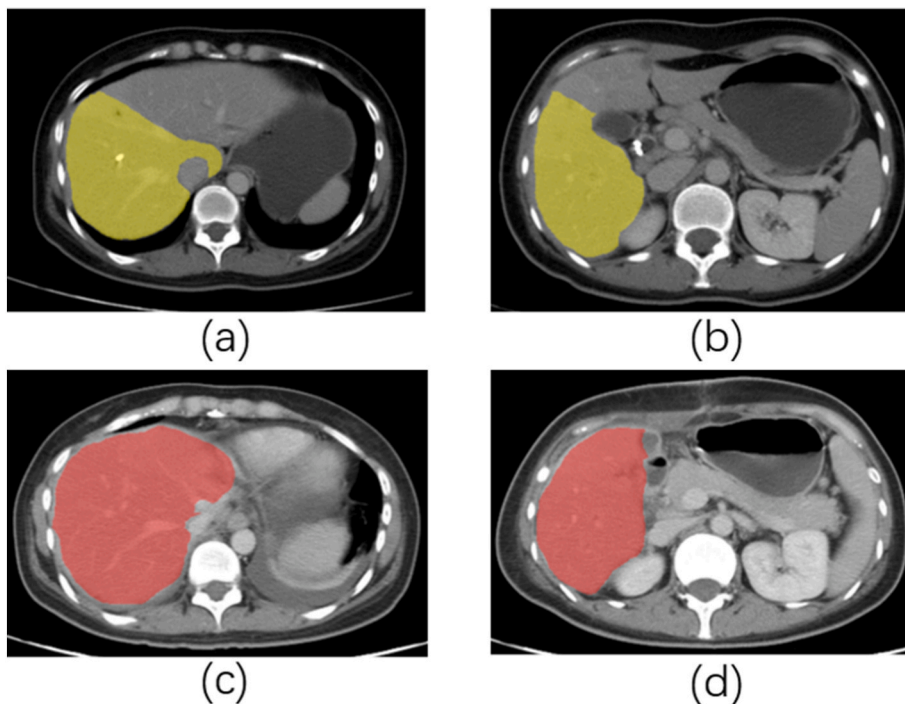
Example of software-driven planning of right hemi-hepatectomy. (A–D) Images of the same computed tomography layer of one patient at postoperative.
